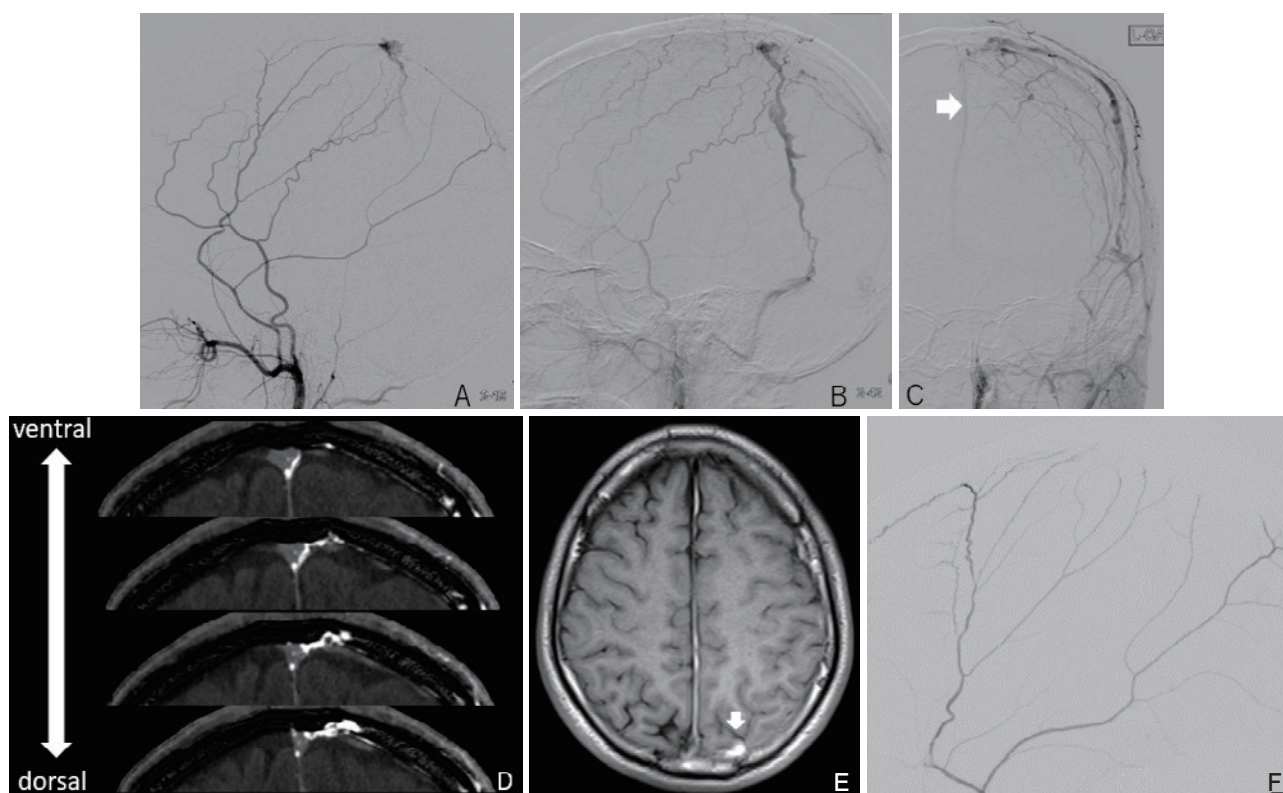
The left external carotid angiogram shows the convexity dural arteriovenous fistula fed by the middle meningeal artery and draining into the transverse sinus via a diploic vein (A, B; lateral view). Some shunt blood flows into the superior sagittal sinus (SSS) (arrow) (C; anteroposterior view). Angiographic multi-planar reconstruction coronal images show that the shunt blood flows into the SSS via a dilated meningeal vein without involving a cortical vein (D). The thickest part of the hematoma coincided with the dilated meningeal vein on T1-weighted magnetic resonance imaging (arrow) (E). The arteriovenous fistula was occluded by two coils and 20% n-butyl-2-cyanoacrylate (F).
